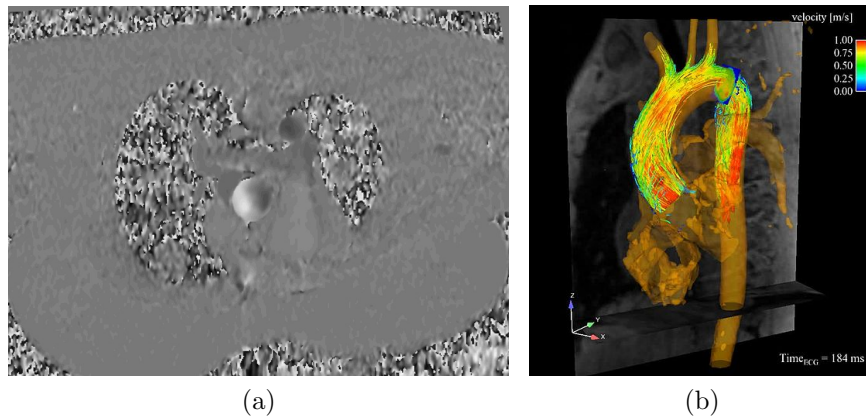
(a) In a flow encoded 2D phase contrast MR image stationary tissue appears gray, air appears as noise (lungs and outside of body) while bright and dark colors show through-plane flow in opposing directions (ascending and descending aorta); (b) The sparse 3D vector field captured by a “4D Flow” CMR image, is shown here as particle traces.
